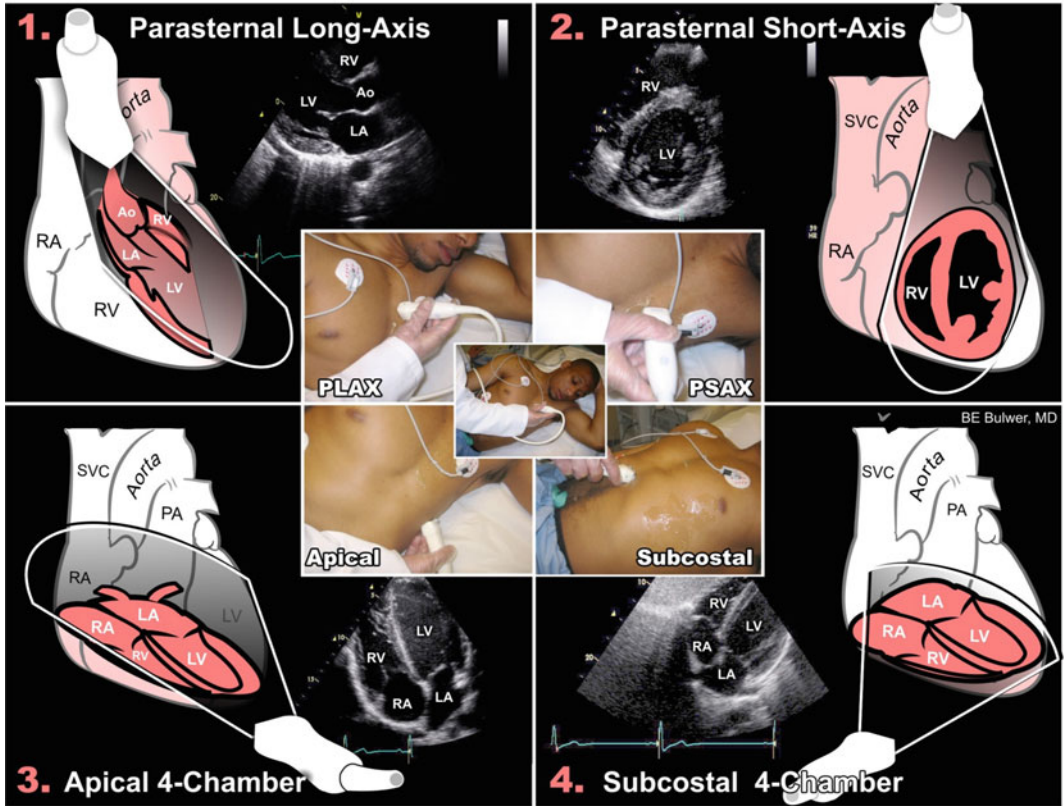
Optimal acquisition of echocardiographic views also requires optimal patient positioning. Panels 1 to 4 are a panoramic overview of patient positioning, transducer windows, and the corresponding echocardiographic view
